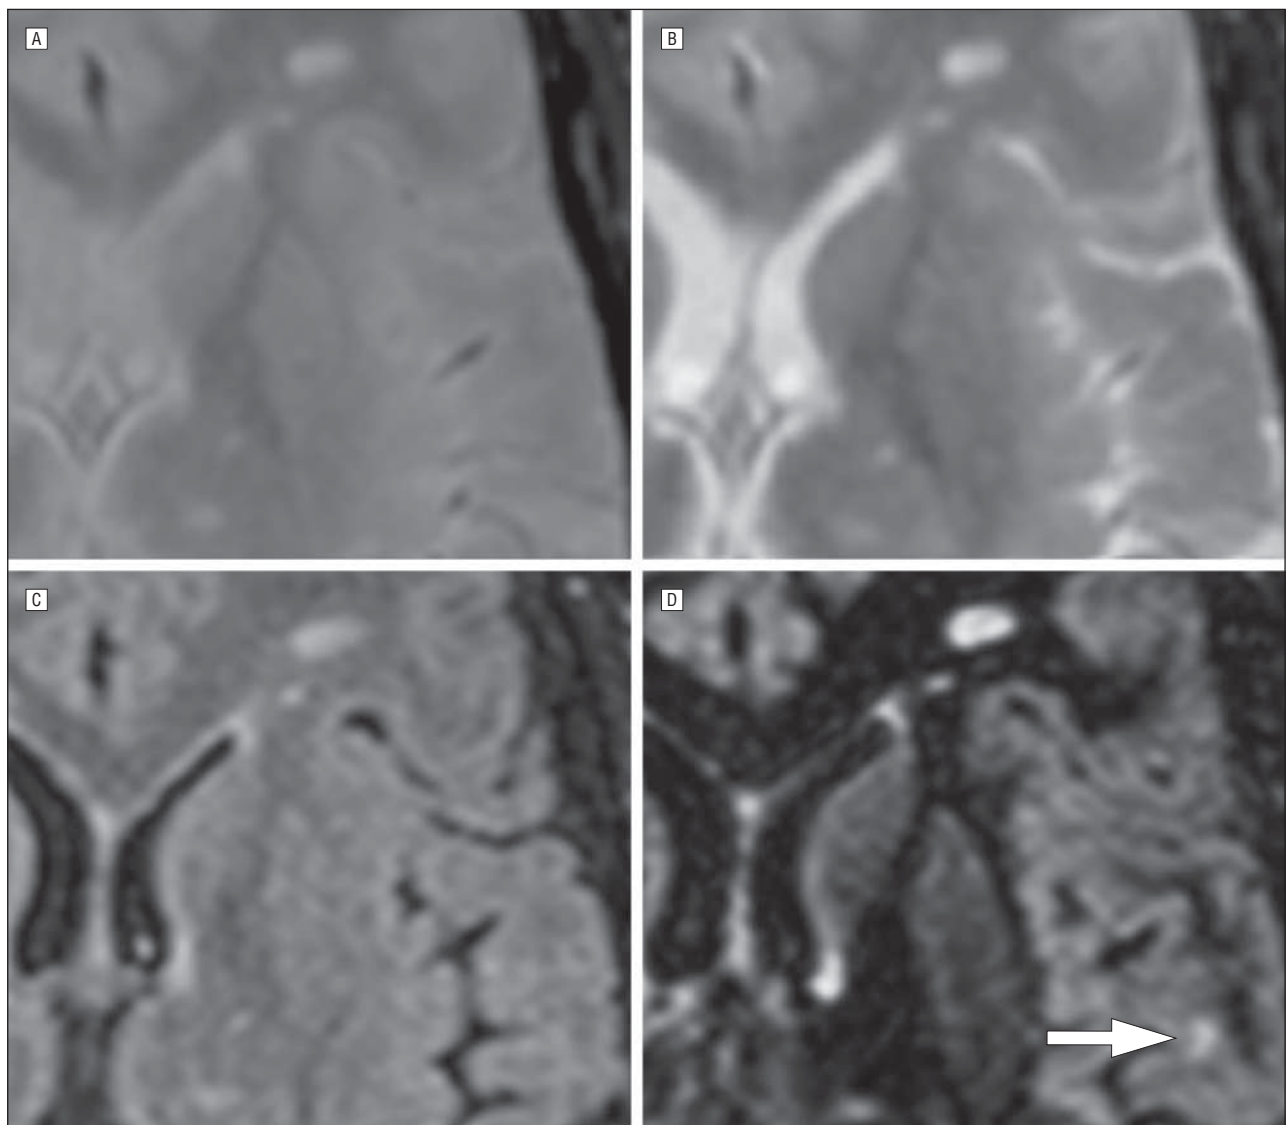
Cortical lesions in multiple sclerosis using double inversion recovery sequences. A and B, Increased cortical multiple sclerosis lesion visibility on double inversion recovery short echo time (A) and long echo time (B) T2-weighted magnetic resonance images. C, Multislab 3-dimensional fluid-attenuated inversion recovery image. D, Multislab 3-dimensional double inversion recovery image showing a cortical lesion (arrow) that is not visible on the other, more conventional, magnetic resonance sequences. White matter lesions around the ventricles are visible on all sequences. Adapted from Geurts et al¹⁷ with permission.
